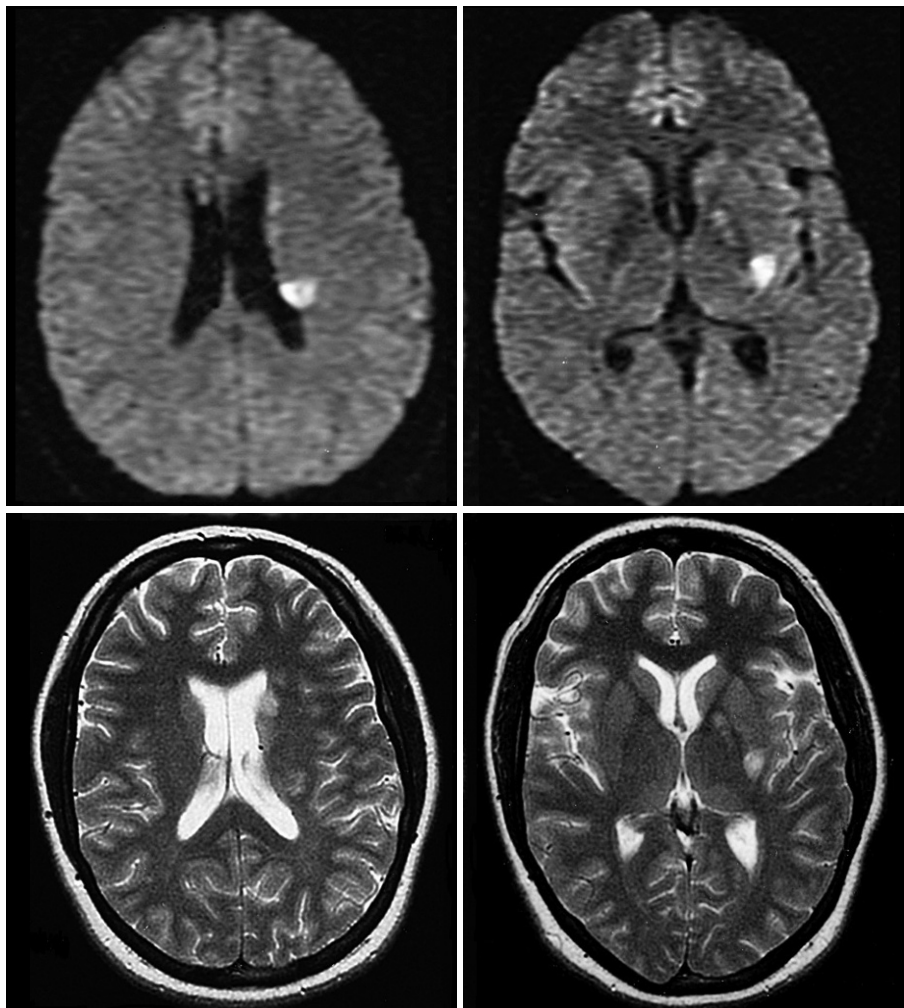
MRI of the brain showing infarcts at the posterior limb of the left internal capsule extending into the putamen, corona radiata, pericallosal white matter, and posterior frontal centrum semiovale.
